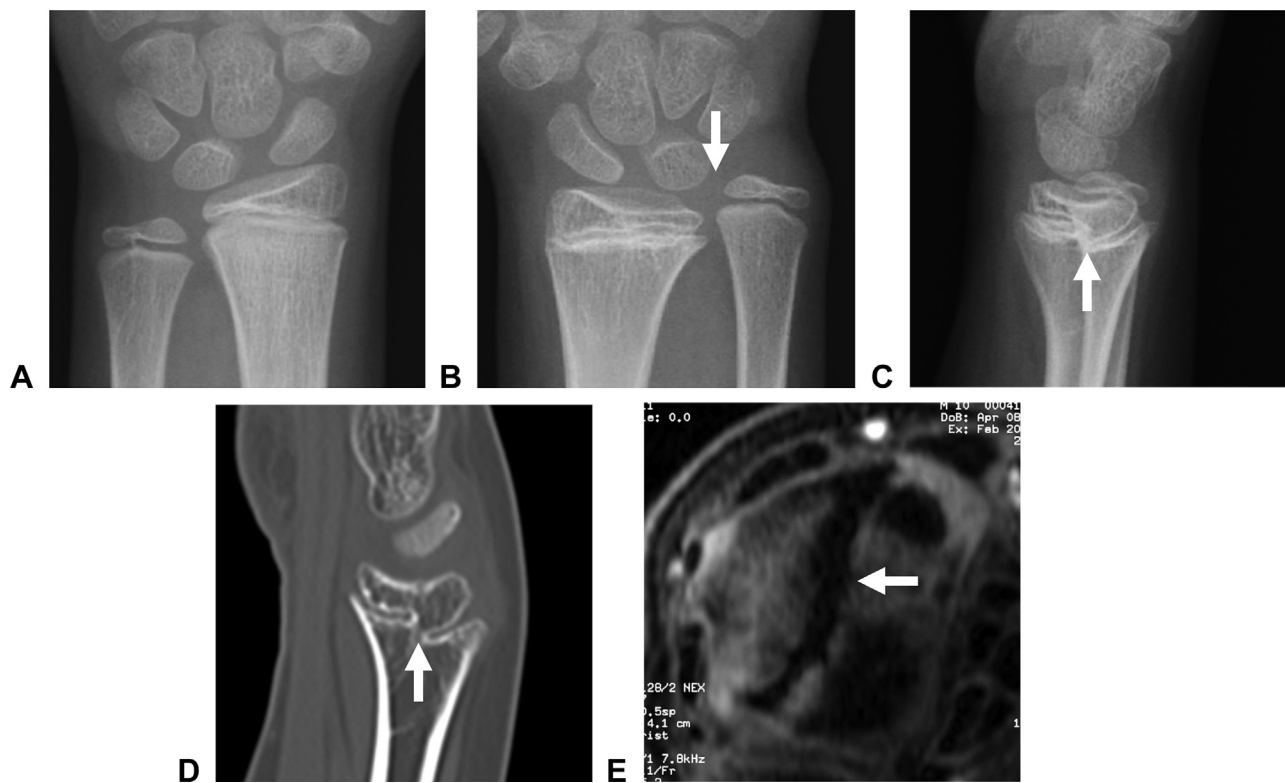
A Radiograph of the left hand of the patient in case 1, contralateral side. B Radiograph of the right hand of the patient in case 1 demonstrates complete growth plate arrest. Ulnar variance was negative (arrow). C Radiograph of the right hand demonstrates clearly the formation of a physeal bar (arrow). D A CT scan sagittal image clearly shows physeal bar formation (arrow). E T1-weighted axial MRI. The physeal bar (arrow) extends in a radioulnar direction. This is the linear type according to Peterson's classification.³
